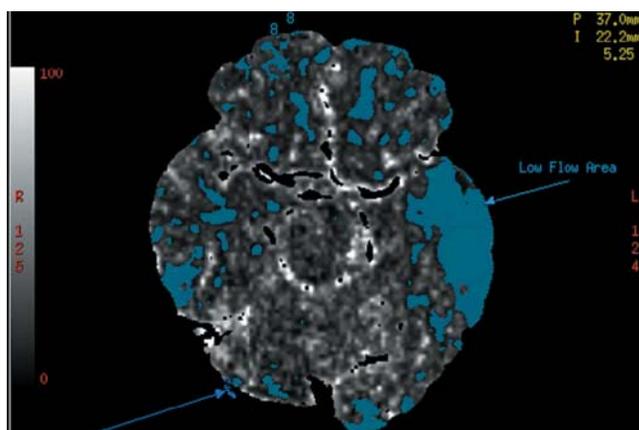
Perfusion CT data demonstrate large ischemia focus in the left temporal lobe.
